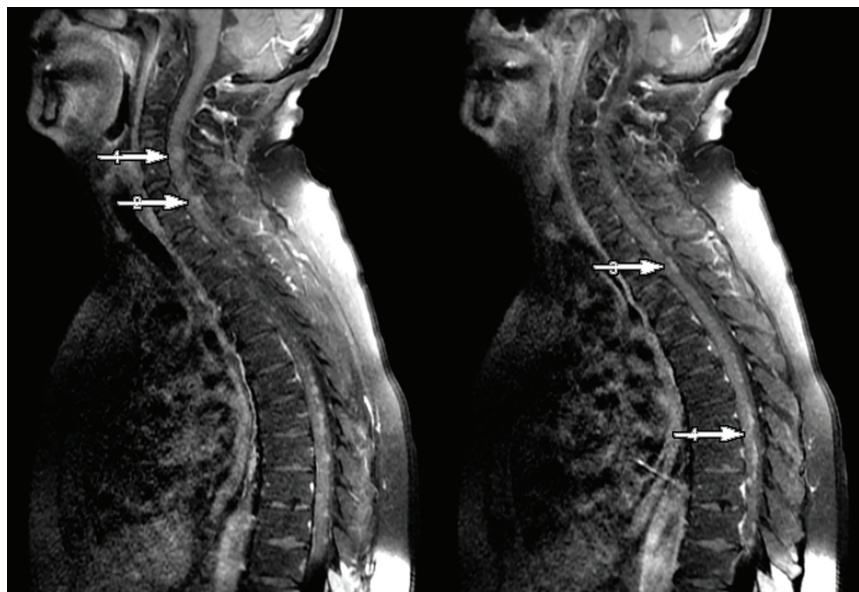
Post-contrast sagittal T1-weighted spinal magnetic resonance imaging (MRI), images of the same patient reveal subtle nodular contrast enhancement (white arrows) in the cervical and thoracic spinal cord, corresponding to the hypermetabolic foci observed on ¹⁸F-fluorodeoxyglucose positron emission tomography/MRI, although lesion conspicuity is limited.
